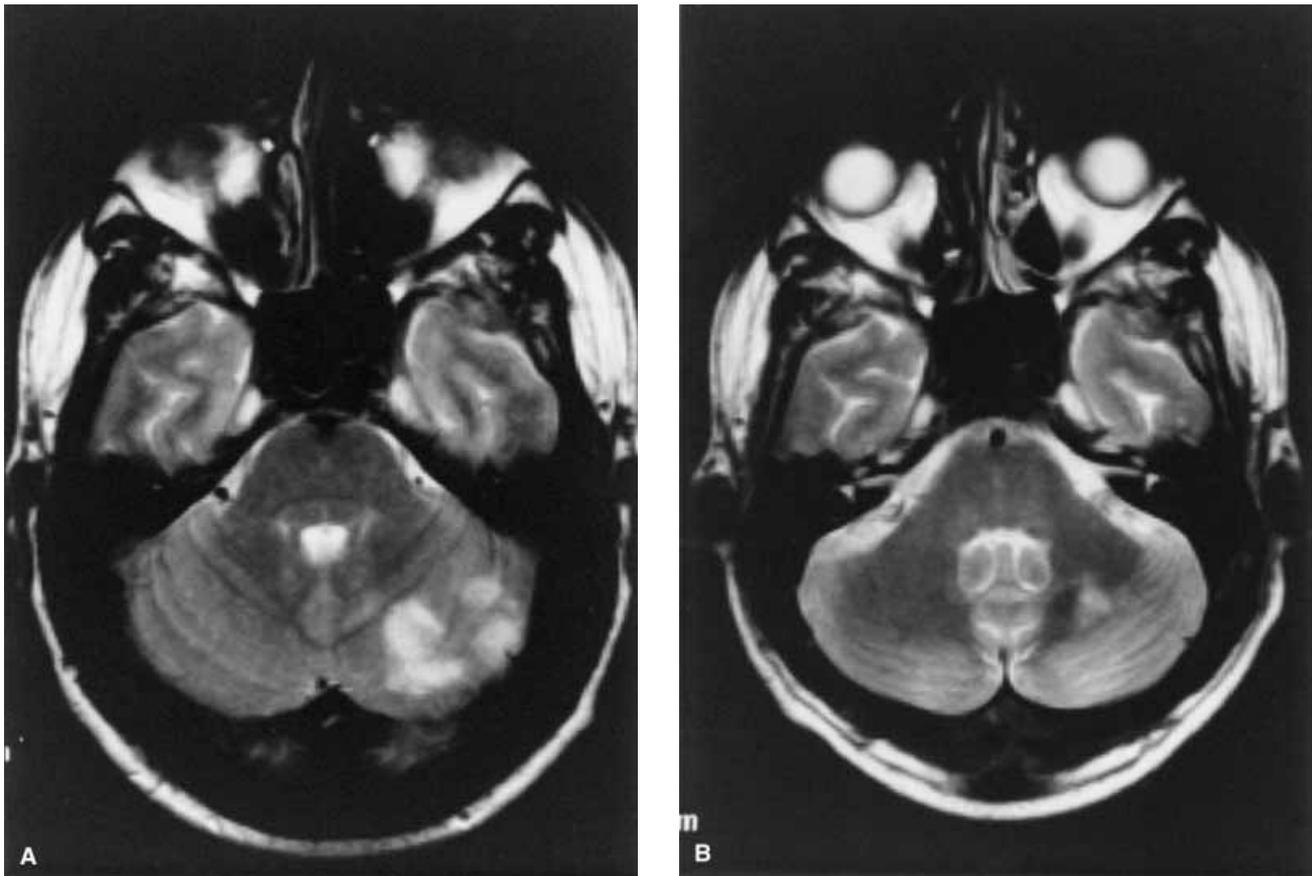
(A) CNS MR imaging in T₂-weighted sequences showing demyelinating lesions involving the cerebellum. (B) Marked improvement of cerebellar MR lesions after α -interferon therapy.
